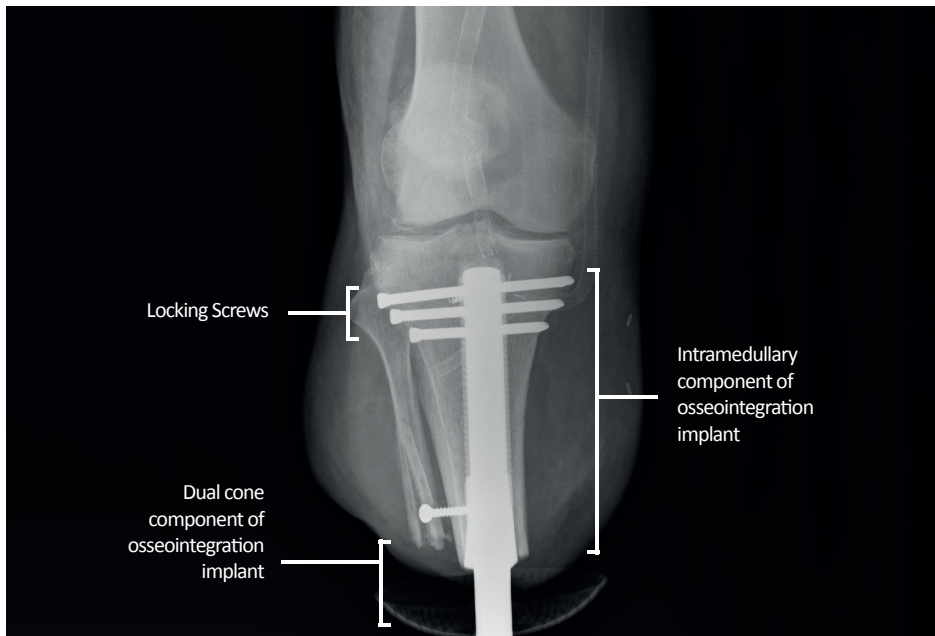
Representative radiograph of the osseointegration implant press-fit into the residual tibia of a patient with transtibial amputation and a history of vascular disease
